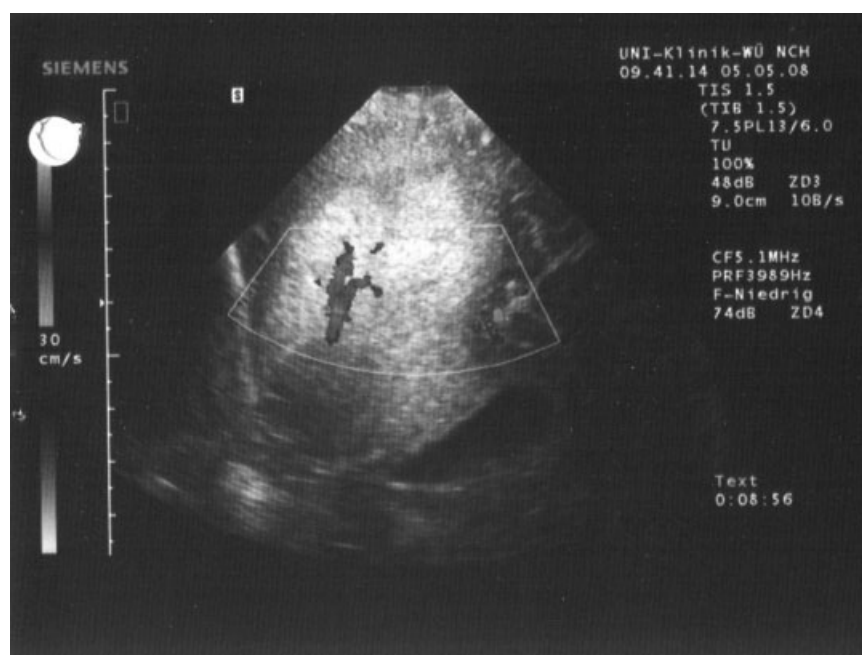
Intraoperative ultrasound demonstrating a tumor with close contact to an arteriovenous malformation.
